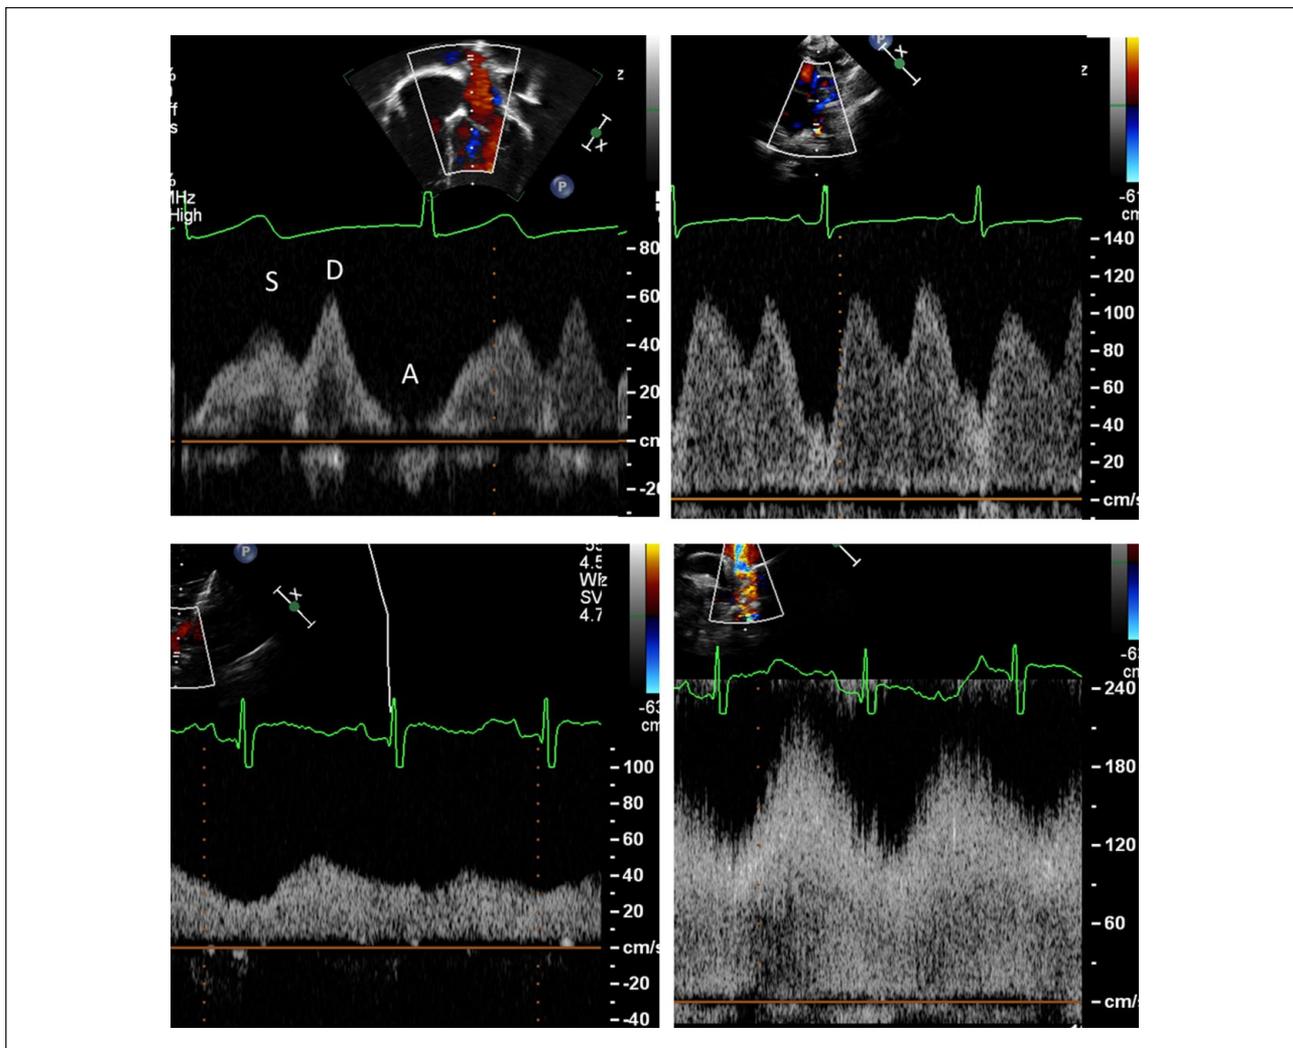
Pulmonary venous spectral Doppler patterns from transthoracic imaging. A. Normal pulmonary vein Doppler from the right upper-pulmonary vein from apical views. The distinct phases of pulmonary venous flow are seen. Flow reversal is typical in atrial systole. B. Unobstructed pulmonary venous pattern with a high-flow state, taken from high parasternal short-axis views. Neonates with high pulmonary blood flow will frequently have elevated velocities relative to normal, but individual pulmonary waveforms are noted. The a-wave returns near baseline during atrial systole for this neonate with truncus arteriosus. C. Pulse-wave Doppler in the left lower-pulmonary vein demonstrates decreased cardiac cycle phasicity and lack of return to baseline or a-wave reversal in this high parasternal short-axis view. This pattern can be seen with mildly obstructed pulmonary veins or pulmonary veins proximal to the site of obstruction. D. Pulse wave Doppler at the connection of the vertical vein to the innominate (from suprasternal notch views) shows high velocity and turbulence consistent with obstruction. The measured mean gradient is 8 mm Hg. Abbreviations: S, systole; D, early diastolic filling; A, atrial systole.
